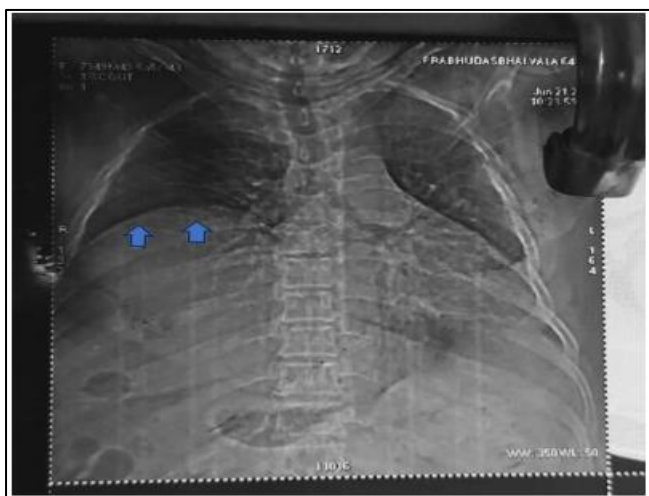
Chest X-Ray showing Elevated Right Hemidiaphragm
